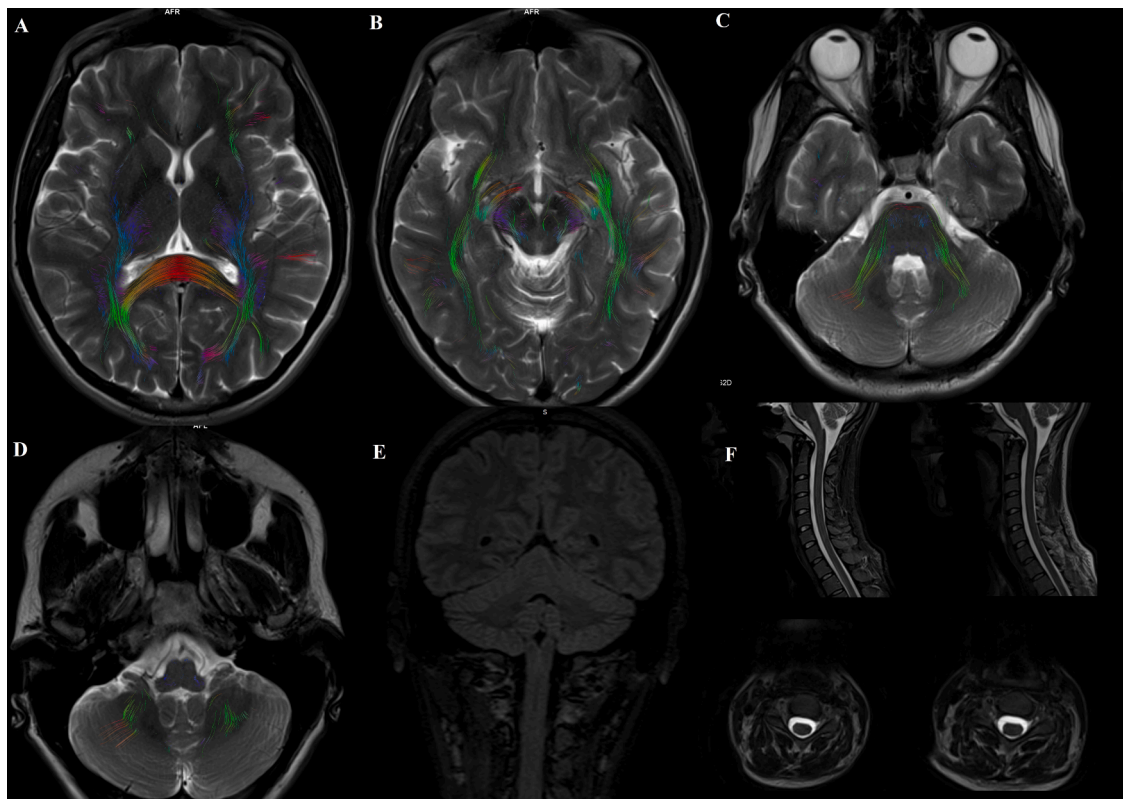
Final follow-up MRI performed within 6 months in other MRI unit (Bioskaner UMB). Axial T2 color-coded white matter fiber tractography (A–D) at the levels of previously affected areas show intact white matter tracts. Coronal 3D-FLAIR (E), sagittal STIR and T2-weighted images and axial T2-weighted images (F) demonstrate complete resolution of the previously seen signal alteration within cerebrum, cerebellum and spinal cord.
